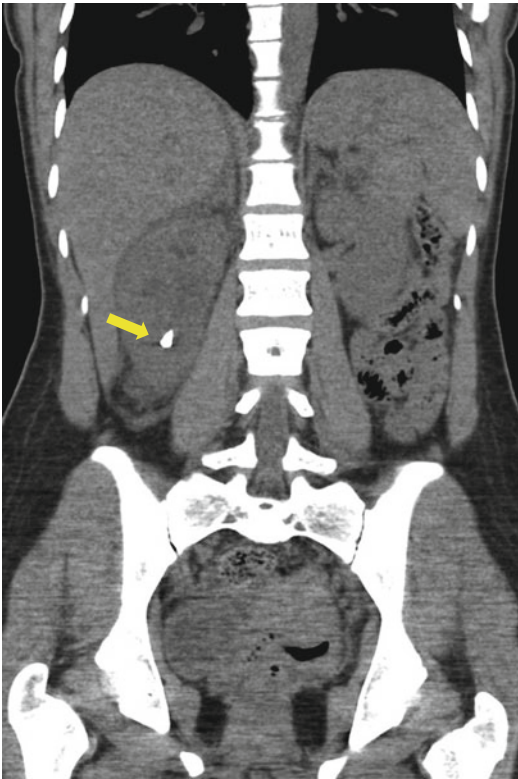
Coronal CT scan image demonstrating a right lower pole renal stone (yellow arrow)
